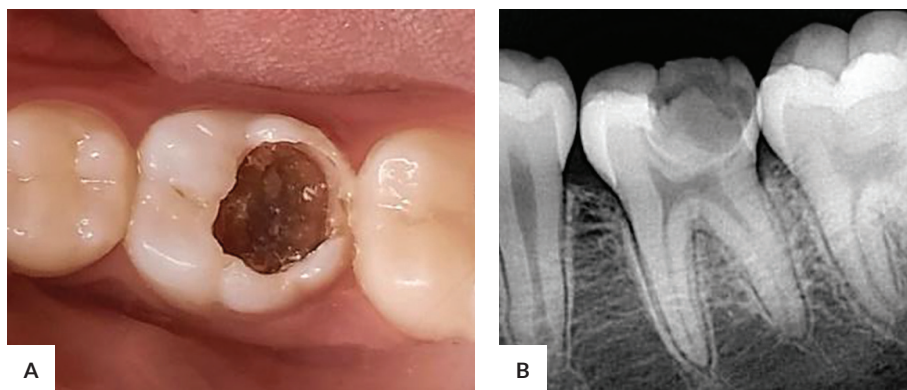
Initial (A) clinical and (B) periapical radiograph.
